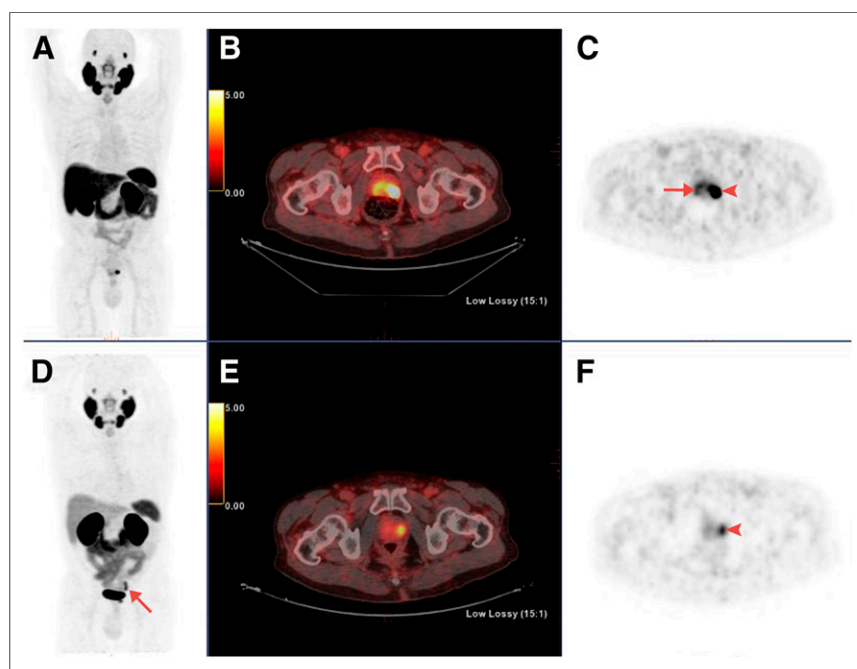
Maximum-intensity projections, transaxial fusion, and PET images of ^{18}F -PSMA-1007 (A–C) and ^{68}Ga -PSMA-11 (D–F) PET/CT scans of 67-y-old patient with GS 8 and PSA 4.9 ng/mL. Marked uptake is seen in urinary bladder and left ureter (arrow) on maximum-intensity projection image of ^{68}Ga -PSMA-11 (D), as opposed to nearly negligible ^{18}F -PSMA-1007 urinary excretion (A). Dominant lesion in left prostatic lobe is evident on both scans (arrowheads). However, second lesion is seen in right lobe only on ^{18}F -PSMA-1007 scan (arrow in C), later verified on pathology as true malignant lesion.
